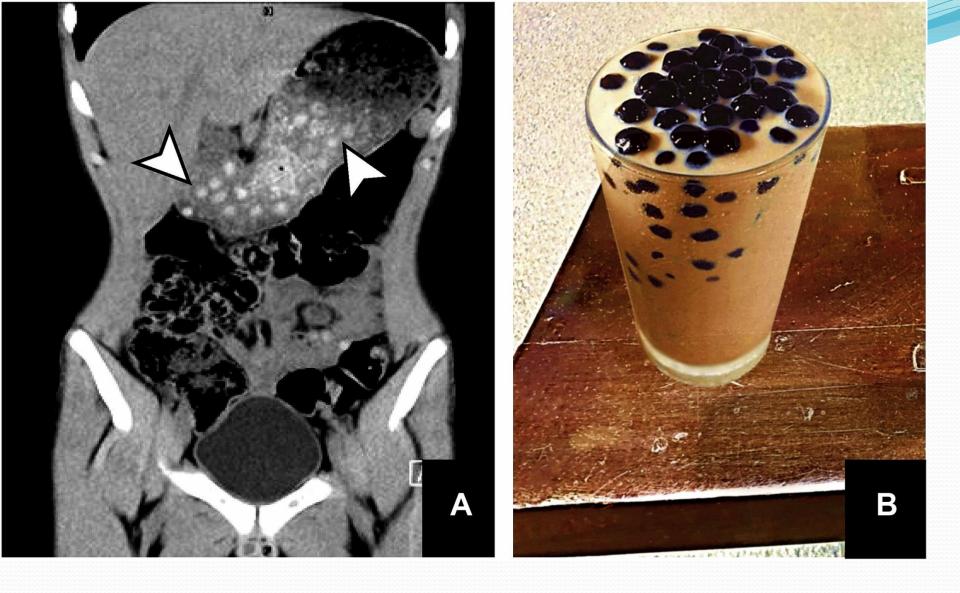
Reconstructed nonenhanced abdominal CT revealing multiple small round hyperdensities (arrowheads) in the distended stomach.
